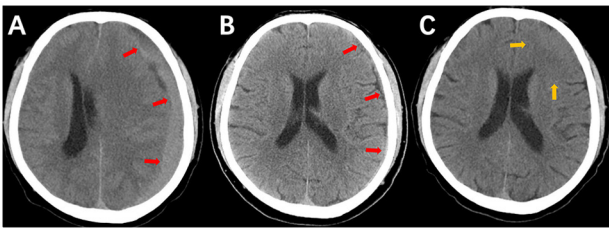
Images captured prior to the glioma's identification. (A) Left frontotemporal parietal subdural hematoma, accompanied by a cerebral hernia (red arrows), was observed in June 2023 (CT). (B) A left frontotemporal parietal subdural hematoma accompanied by cerebral hernia (red arrows) was observed in July 2023 (CT). (C) In September 2023 (CT), the density of the left frontal gyrus was observed to be slightly higher than normal brain tissue (yellow arrow, CT).
